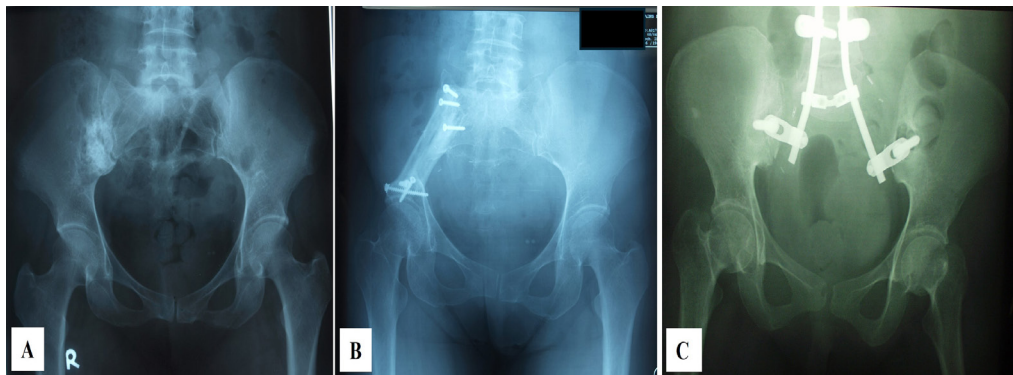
Reconstruction of the posterior pelvic ring following resection for chondrosarcoma. (A) Preoperative plain radiograph showing a tumour involving the ilium (P1) and (B) the postoperative plain radiograph after resection and reconstruction with a non-vascularised fibular strut autograft (Case #9). (C) Postoperative plain radiograph following sacral resection (P4) with reconstruction using posterior iliolumbar instrumentation and fusion (Case #10)
